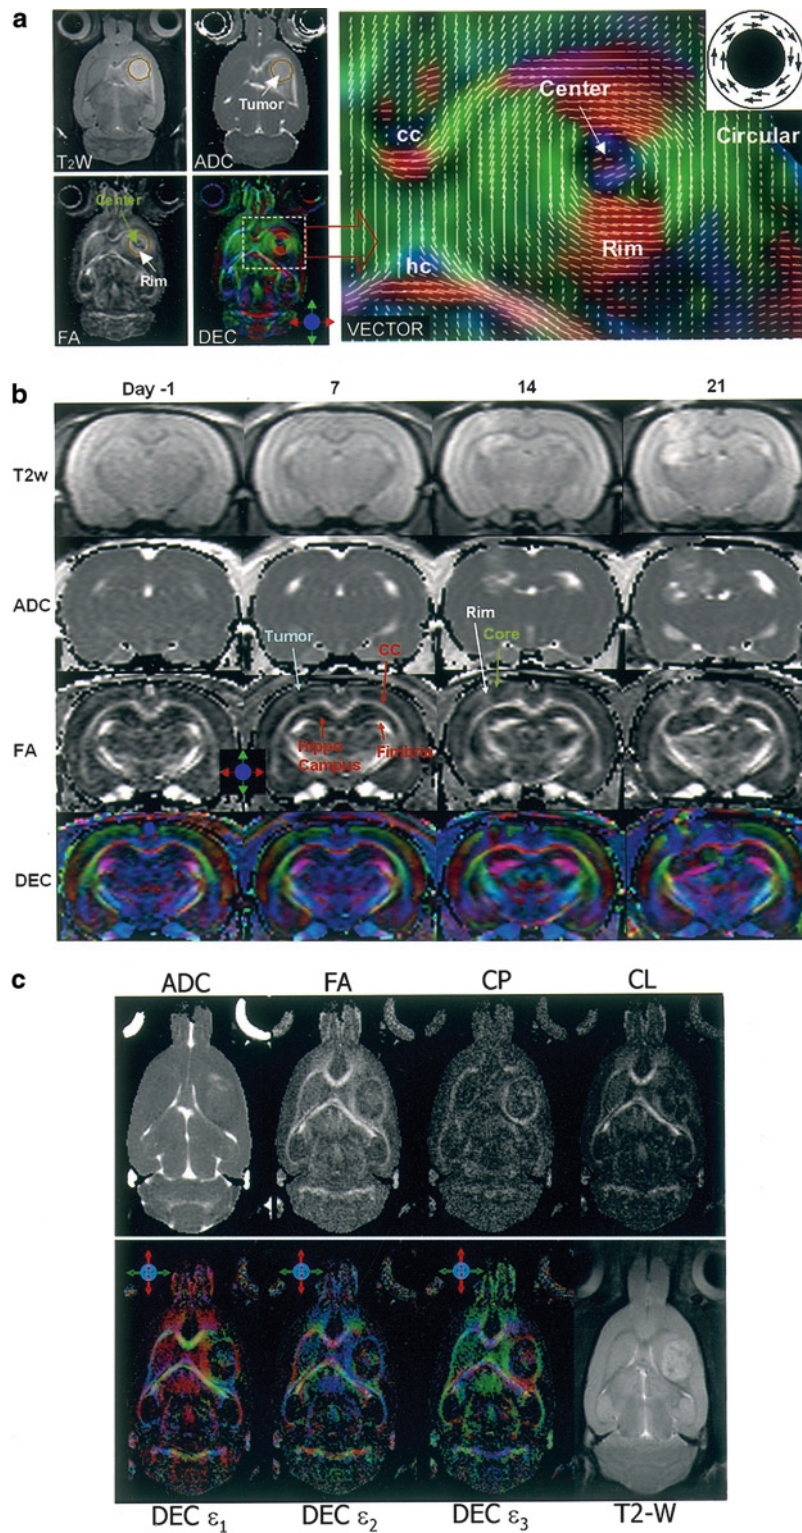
(a) In vivo MR images of 9L gliosarcoma brain tumor model at post-implantation day 11. cc, corpus callosum; hc, hippocampal commissure. The tumor regions are hyperintense
